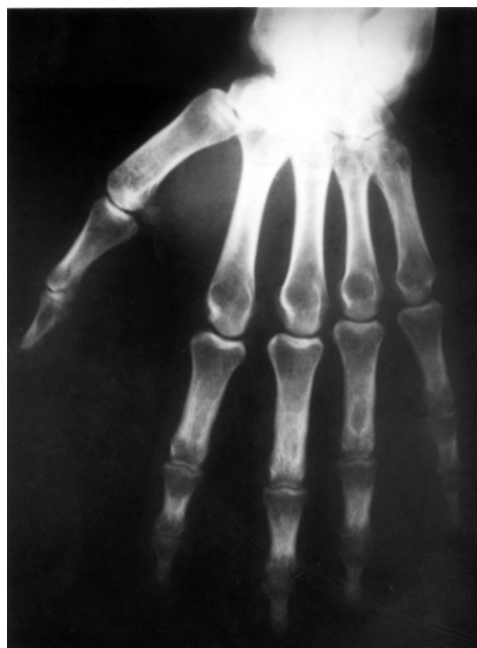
X-ray of the hand showing short metacarpi
